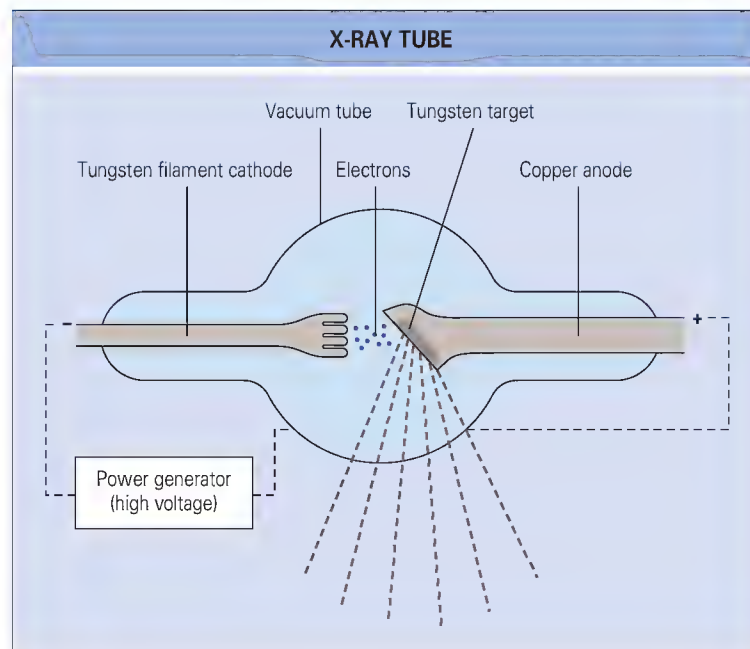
The x-ray tube consists of a cathode tube filament producing electrons, a tungsten target in a copper anode, and a vacuum tube.
